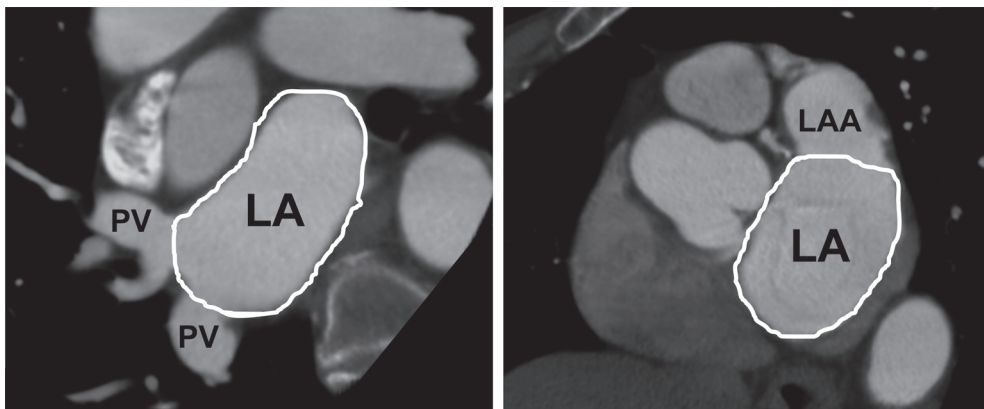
Simpson's rule demonstrated with computed tomographic images in oblique axial view of the left atrium. The white line demonstrates the manual tracings of left atrial area, excluding the pulmonary veins (left panel) and the left atrial appendage (right panel). LA = left atrium, LAA = left atrial appendage, PV = pulmonary vein.
